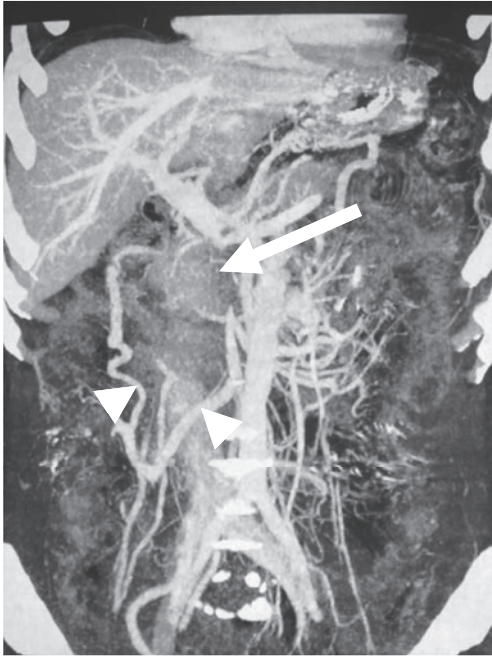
On POD 11, 3-dimensional CT scan showed that the truncated SMV was not visualized at the point of ligation (arrow) and that the diameter of the inferior mesenteric vein had increased (arrowheads).
